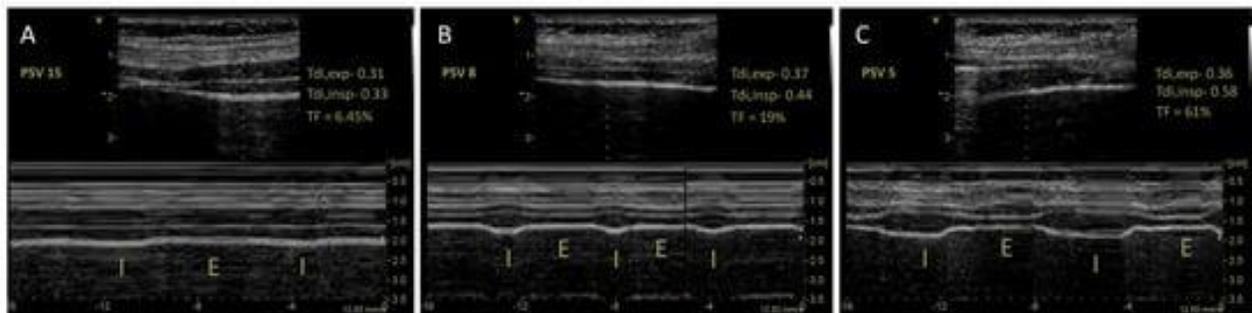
Diaphragm ultrasound to monitor effort. Titrating effort according to thickening fraction (TF). Panel A—Reduced TF suggestive of over-assistance (PSV 15 cm H₂O). Panel B—“Ideal” TF suggestive of appropriated effort (PSV 8 cm H₂O). Panel C—Increased TF suggestive of under-assistance (PSV 5 cm H₂O).
